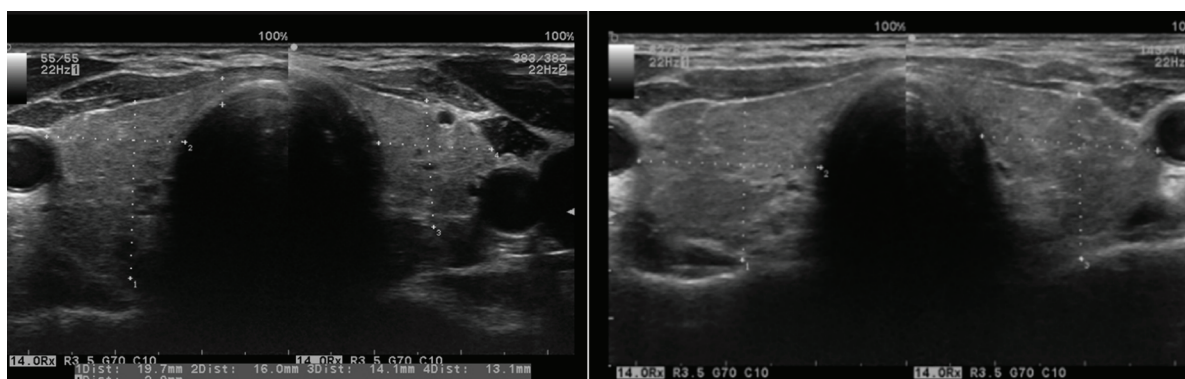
A. Thyroid gland of the upper border size, with small- and medium-sized hypoechogenicity as in autoimmune thyroid disease. B. Thyroid ultrasonography in the same patient after 1 year – discrete inhomogeneity persists, with increasing fibrotic changes
